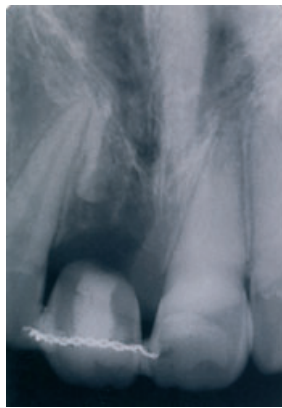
Radiograph 24 months after decoronation showing continuing replacement resorption of root fragment and apposition of bone. The upper left maxillary central and lateral incisors show total pulpal canal obliteration.
